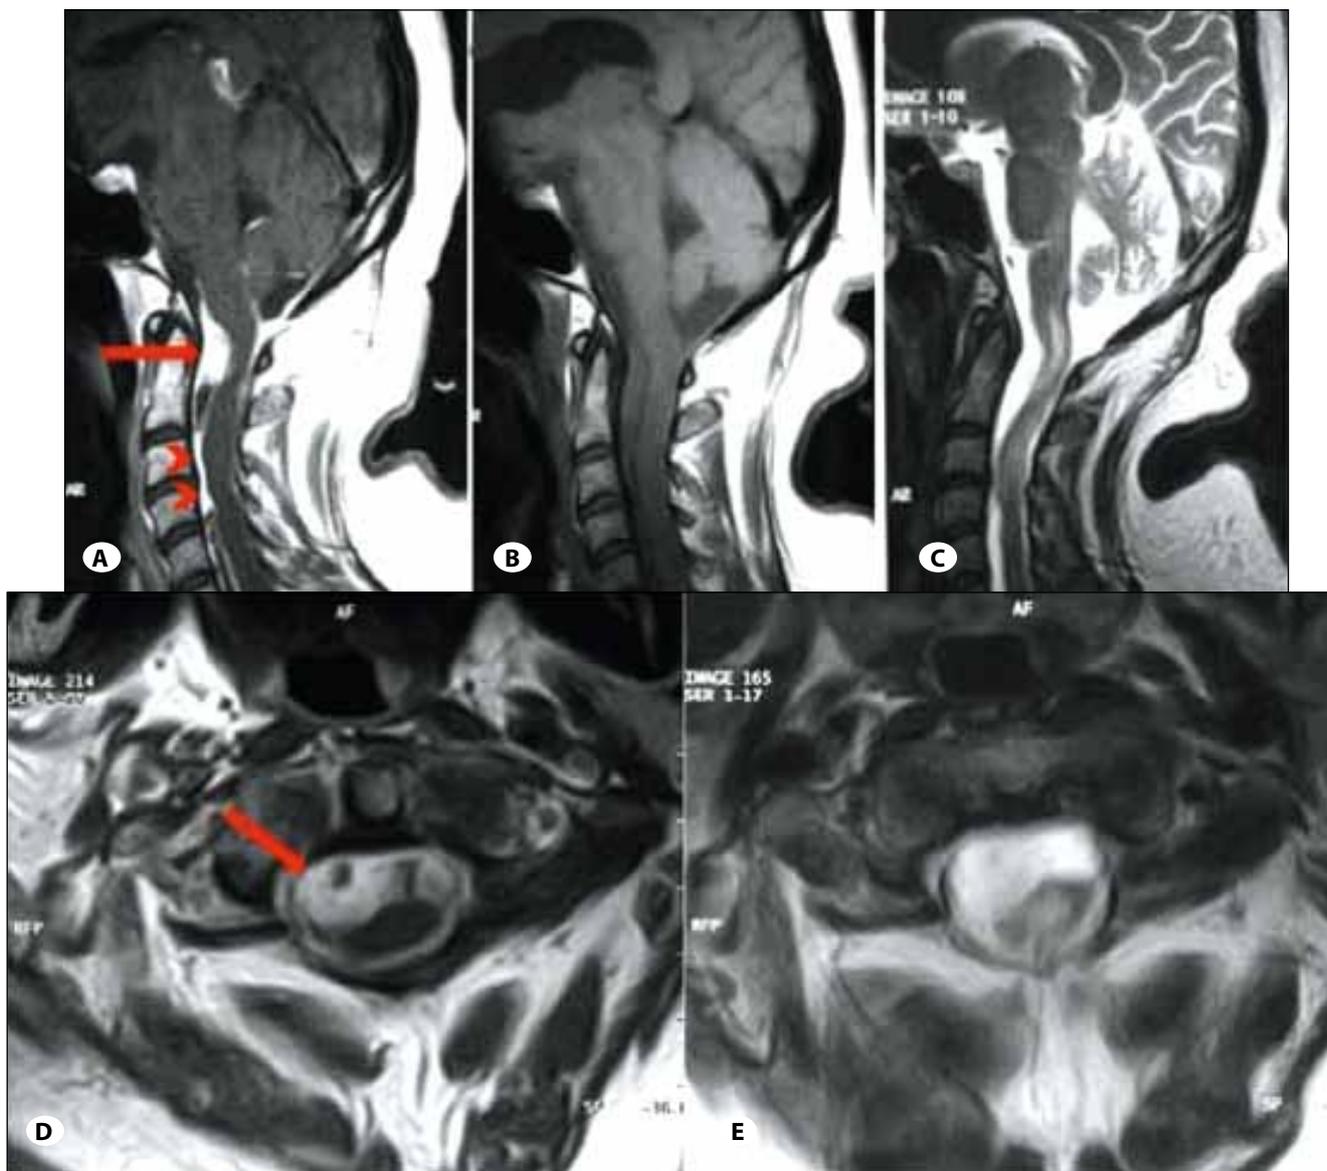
The MRI-scan of craniocervical junction with gadolinium contrast agent shows no sign of pathology consistent with presence of intracranial mass lesion (2A). Note that the dural thickening exhibits intense contrast material enhancement (2a, arrows), shows hypointensity on T1-weighted images (B) and is heterogeneously hyperintense on T2-weighted images (C). The axial section of MRI-scan with gadolinium contrast agent showing C1 level reveals diffuse leptomeningeal enhancement with a nodular lesion (D, arrow). T2-weighted axial section of MRI image shows hyperintensity anterior to the spinal cord (E).
